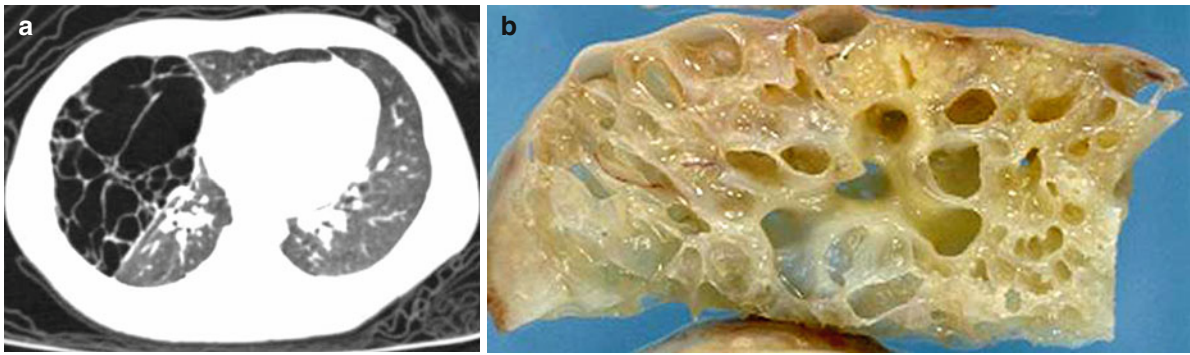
Examples of type I PPB (different patients shown). (a) Axial chest CT image. Characteristic of multiloculated, air-filled cyst. CCAM may be radiographically identical. (b) Gross
